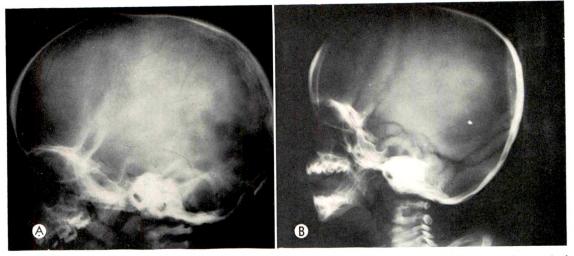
(A) Note the large skull with everted lips of the anterior fontanel in this child presenting typical facial features of gargoylism. (B) Other features of this condition are seen on this roentgenogram. The sutures are wide and a "shoe" shaped sella turcica is demonstrated.
